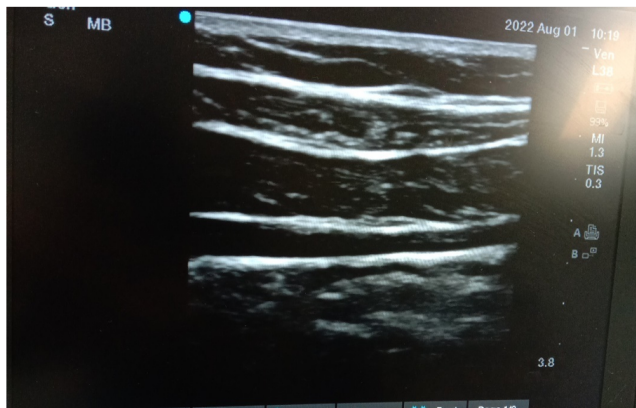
Ultrasound- guided image of Transversus abdominis plane
